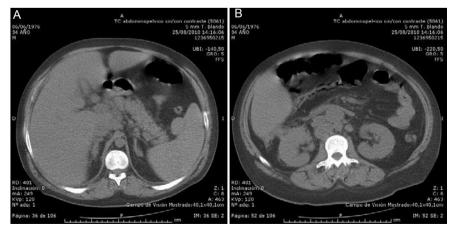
Abdominal CT scan demonstrates A) pathological hepatic lymph nodes and B) retroperitoneal lymph nodes.
